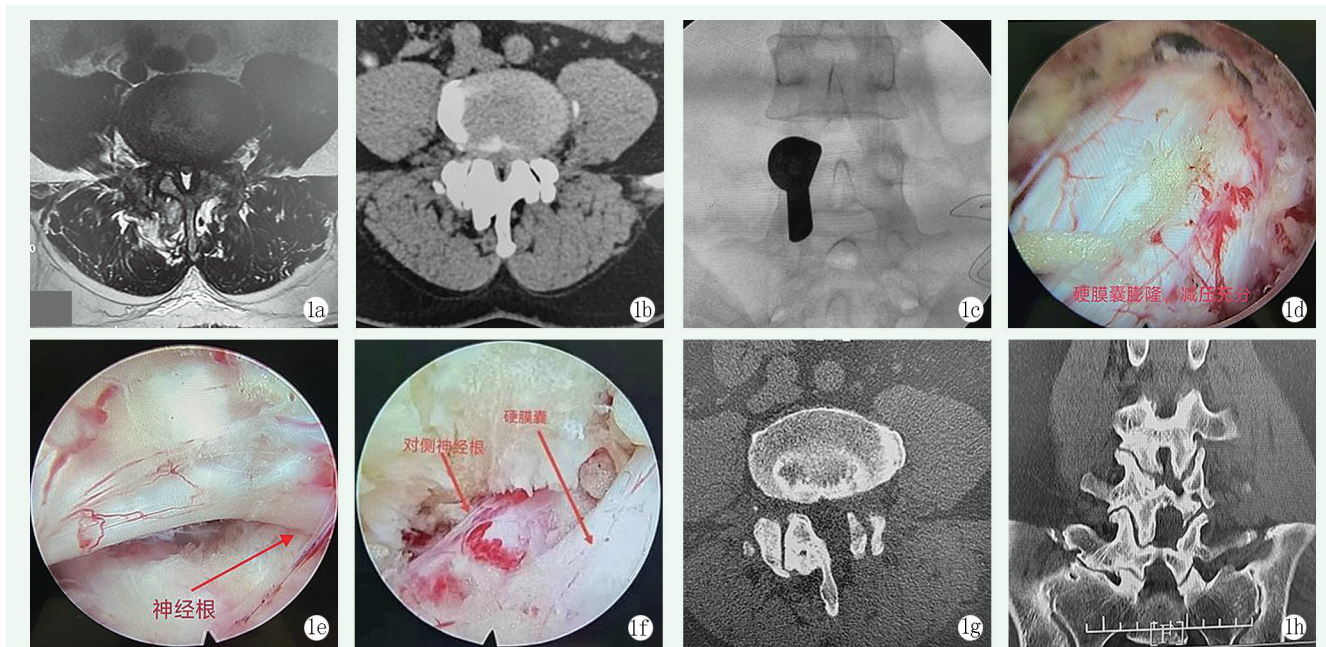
患者男性，65 岁。L_{4/5} 椎管狭窄症，行全内镜 ULBD 手术治疗。1a: 术前腰椎 MRI 显示 L_{4/5} 层面椎管狭窄；1b: 术前腰椎 CT 显示 L_{4/5} 层面椎管狭窄；1c: 术中通道放置；1d~1f: 镜下椎管减压充分；1g, 1h: 术后次日腰椎 CT 显示椎管减压充分。
